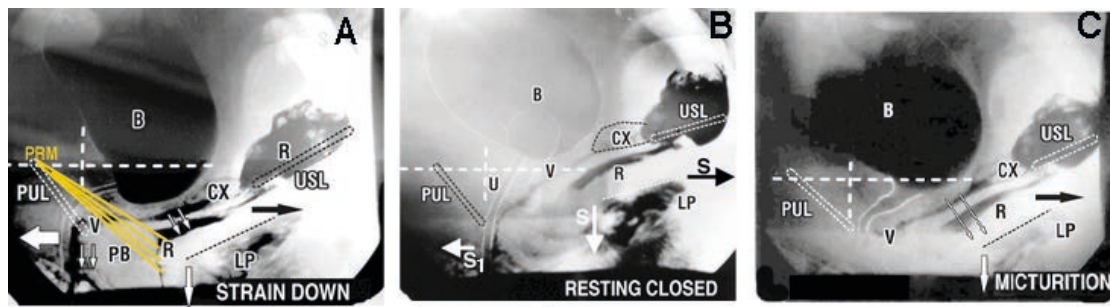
Normal bladder/bowel function Video xray, sitting position. Radio-opaque dye has been injected into the bladder, vagina, rectum, levator plate.
